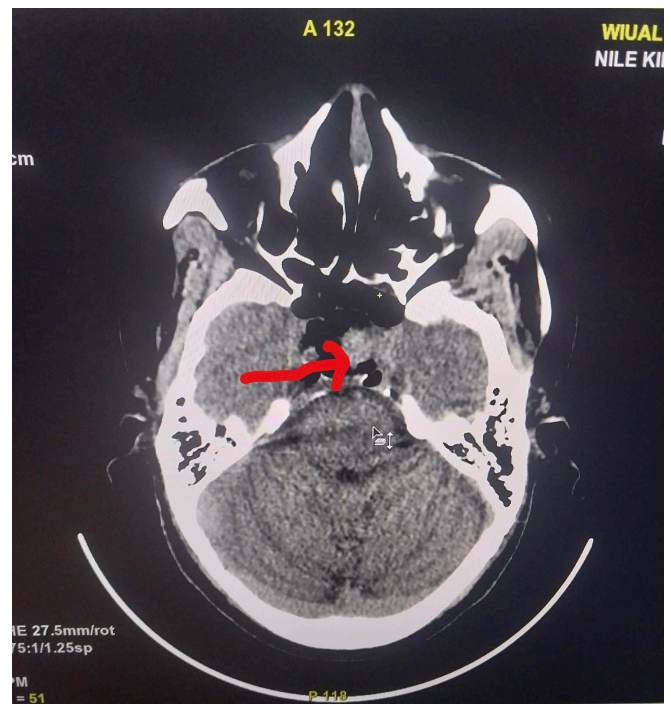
CT scan showing meningocele (hernia of the meninges and brain tissue through the lateral sphenoid sinus wall defect from the middle cranial fossa). (Credit: Dr Justin Rubena Luamaya)
